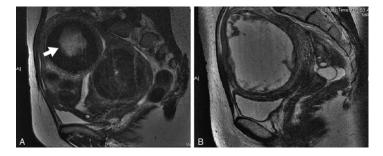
Degenerating leiomyomas seen by T2-weighted magnetic resonance imaging (MRI; a; *arrow*) and by T1-weighted MRI (b) with gadolinium contrast (From Laughlin and Stewart [24], with permission of the American College of Obstetricians and Gynecologists)
